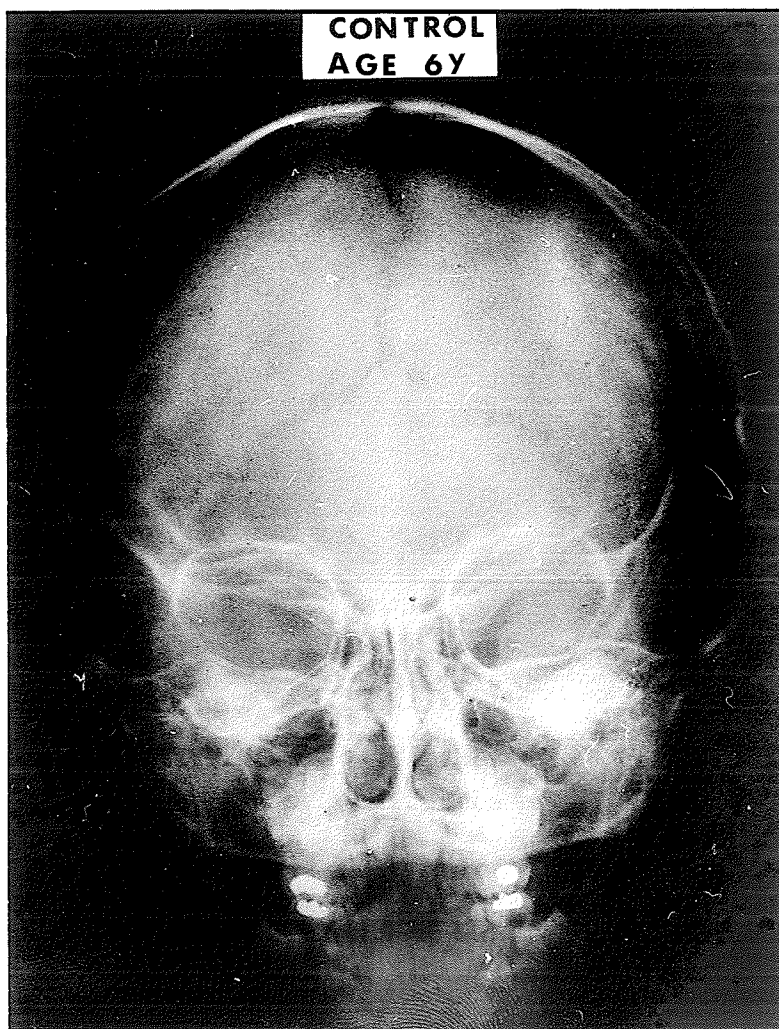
P.A. radiograph of a Control individual showing no patent metopic suture even at a young age and no wormian bones can be identified in the lambdoid suture.
